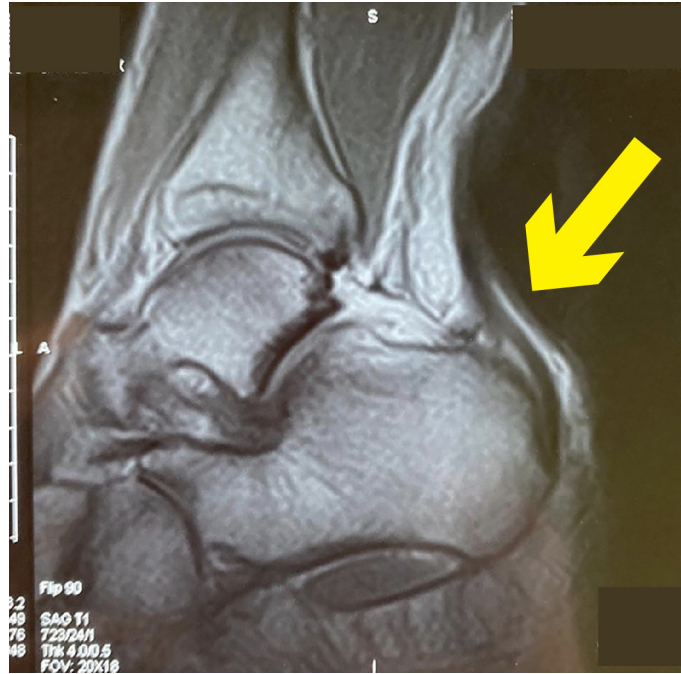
Sagittal T1-weighted spin-echo sequence of the foot and ankle shows the outcomes of surgical procedures. The complete removal of the bursitis and endoscopic resection of the calcaneal exostosis (yellow arrow indicates);
